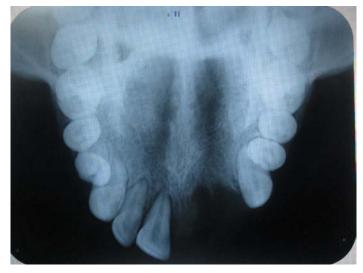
maxillary occlusal radiograph
